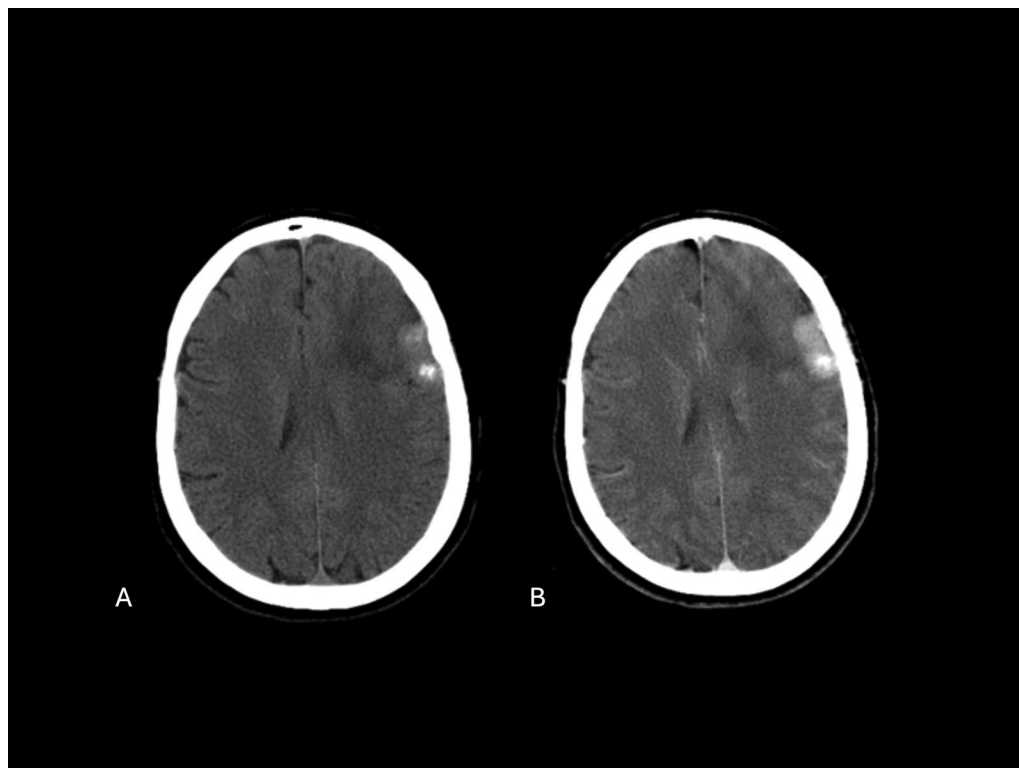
A 54-year-old female, previously healthy, was admitted at the emergency department with seizures followed by vertigo. Brain CT axial images pre (A) and post-contrast (B), revealed an expansile extra-axial left frontal lesion with calcifications and homogeneous enhancement after contrast administration with underlying hypodensity of the parenchyma
